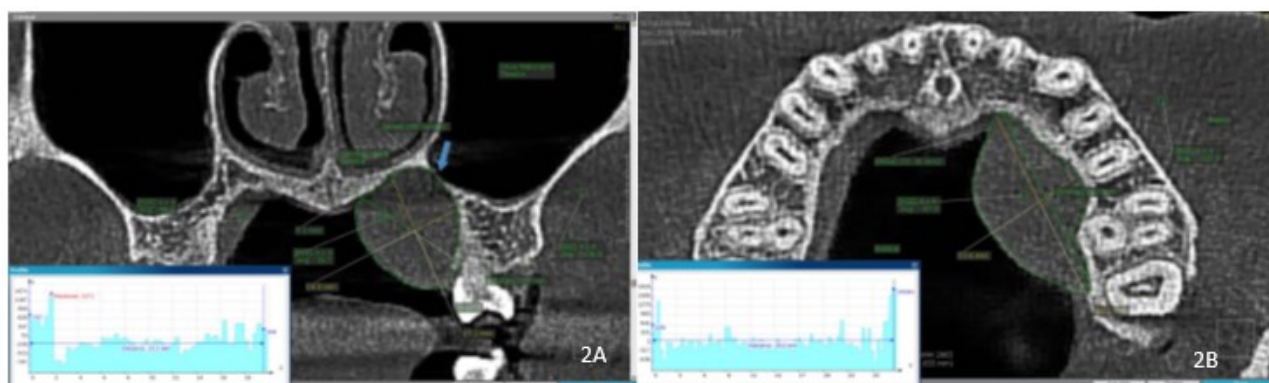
(A) Coronal CBCT section shows a visible lesion covering almost half of the palate, (B) Axial section in the hard tissue did not show any significant changes¹³
